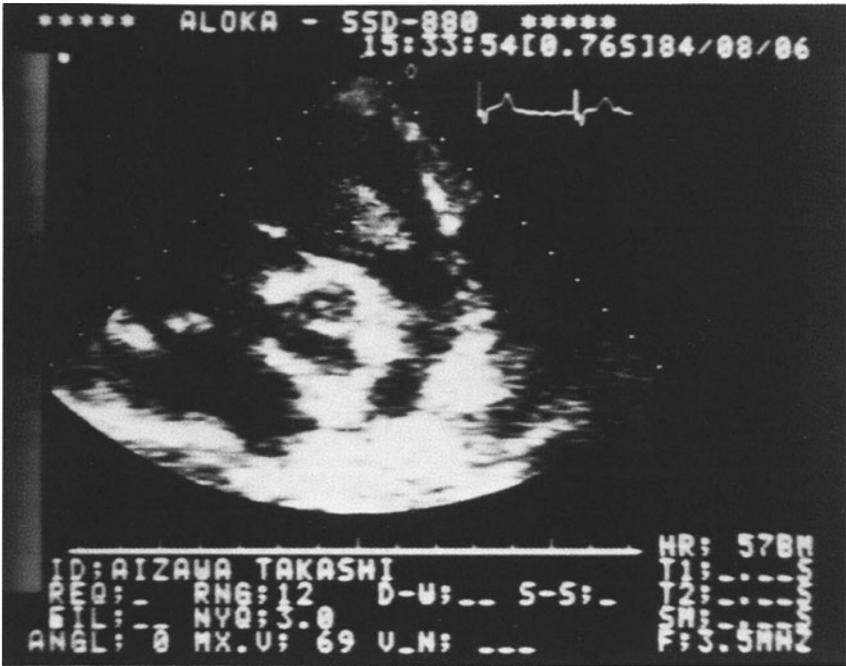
Imaging of pulmonary regurgitant flow. Pulmonary artery and right ventricle were demonstrated in parasternal view, and the image of PR flow was visualized in color (Ao, aorta; PA, pulmonary artery; PR, pulmonary regurgitant; RA, right atrium; RV, right ventricle; and TV, tricuspid valve).
